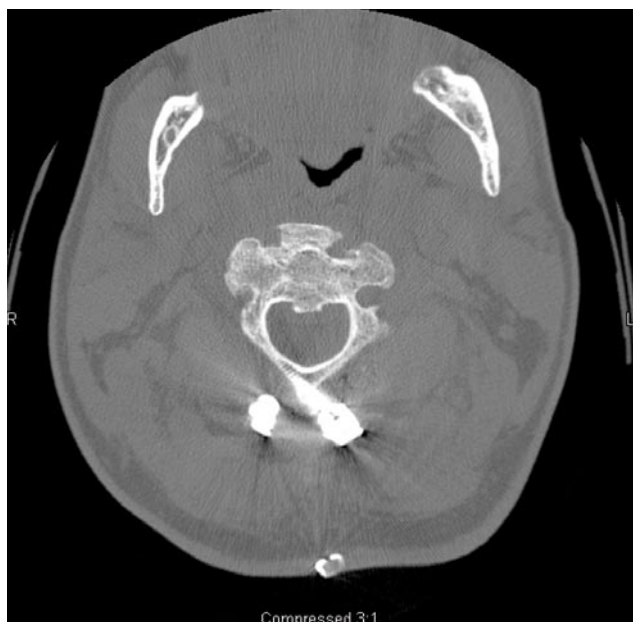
Postoperative axial computed tomography at C2 level shows thin pedicles and medial transverse foramen.
